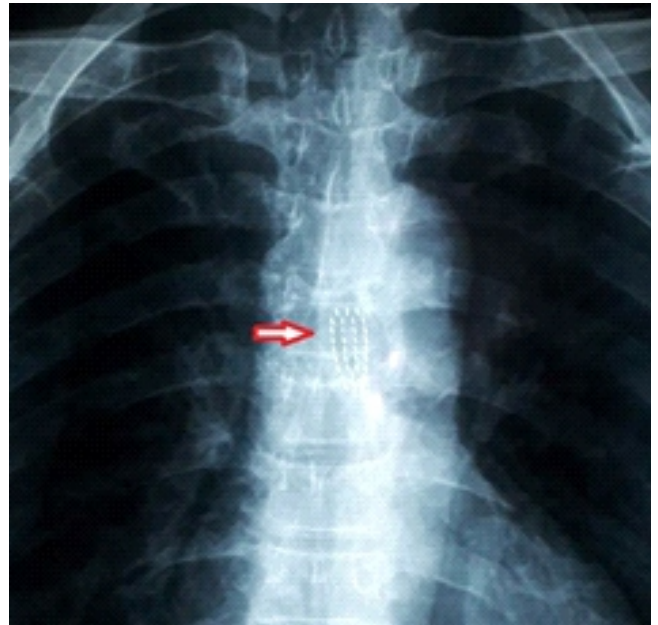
Chest radiograph showing head of the toothbrush
